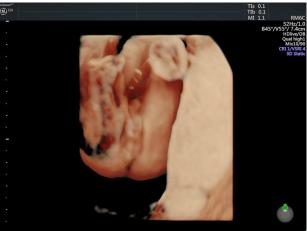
Male phenotypic external genitalia (20 weeks of gestation, 3D static ultrasound examination). 3D: Three-dimensional.
